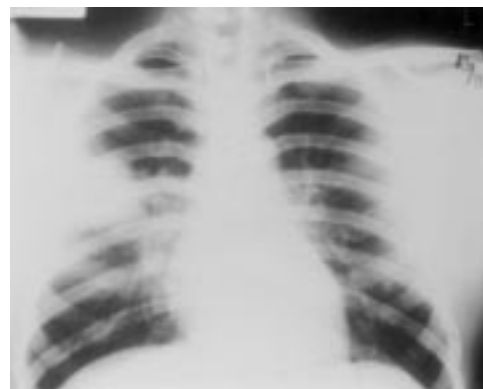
Posteroanterior chest radiograph showing right upper lobe mass due to *Penicillium marneffei*.
